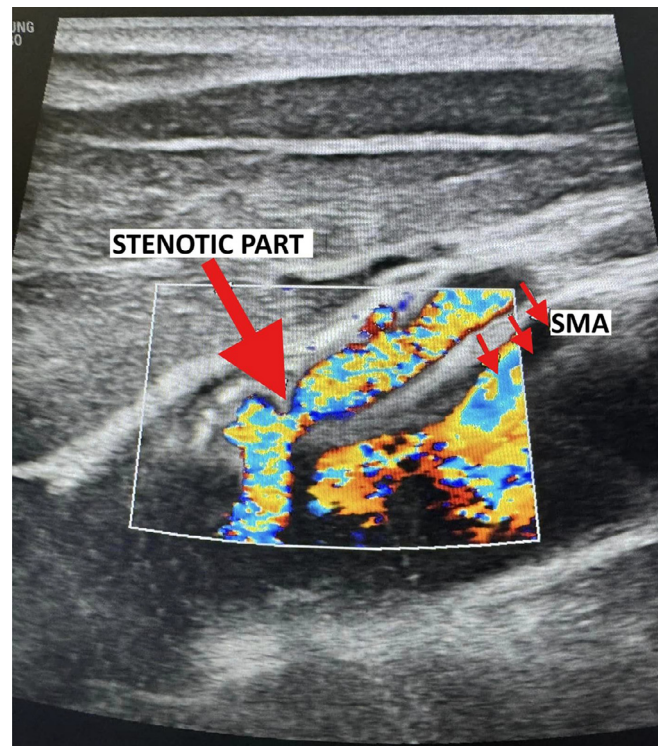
Doppler ultrasonography findings. Showing compression of celiac artery just distal to its origin from abdominal aorta.
